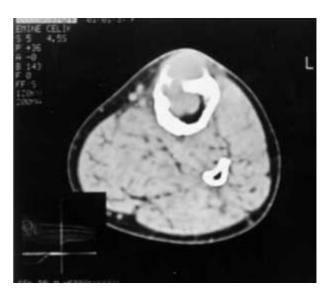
Computed tomography showing cortical destruction with the intra and extra-osseous mass on the anterior aspect of the tibia.
